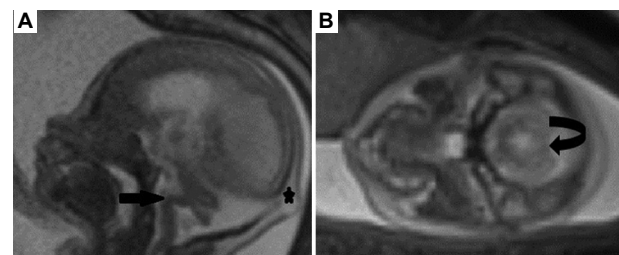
MRI of a 20-week fetus. (A) Sagittal TRUFI and (B) axial HASTE images show kinked pontomesencephalic junction (black arrow), an encephalocele sac (black star), and a dysmorphic, small cerebellum and vermis (black curved arrow).
